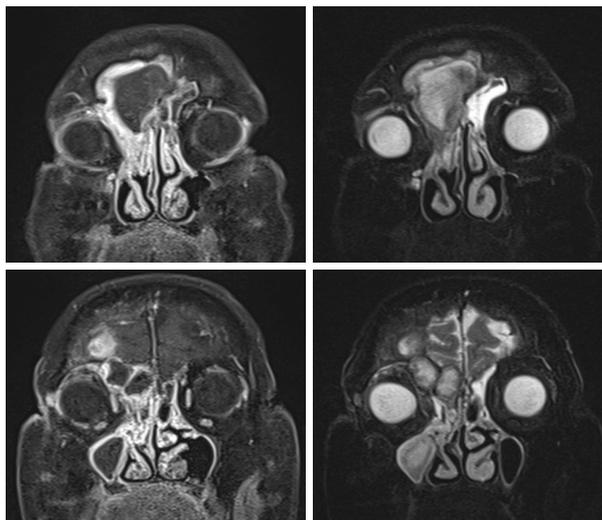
Figure SEQ Figure 1 ARABIC 2 - The preoperative MRI showed the presence of a pluriconcated right frontal mucocele (images A and B) extended in the homolateral ethmoid-maxillary region (images C and D). The T1 weighed sequences (images A and C) show a peripheral hyperintense hemline with central hypointensity while in the T2 weighed sequences (images B and D) the typical hyperintensity of the liquid content leaves room for an isodensity indicative of a long time, partially dehydrated collection.*
